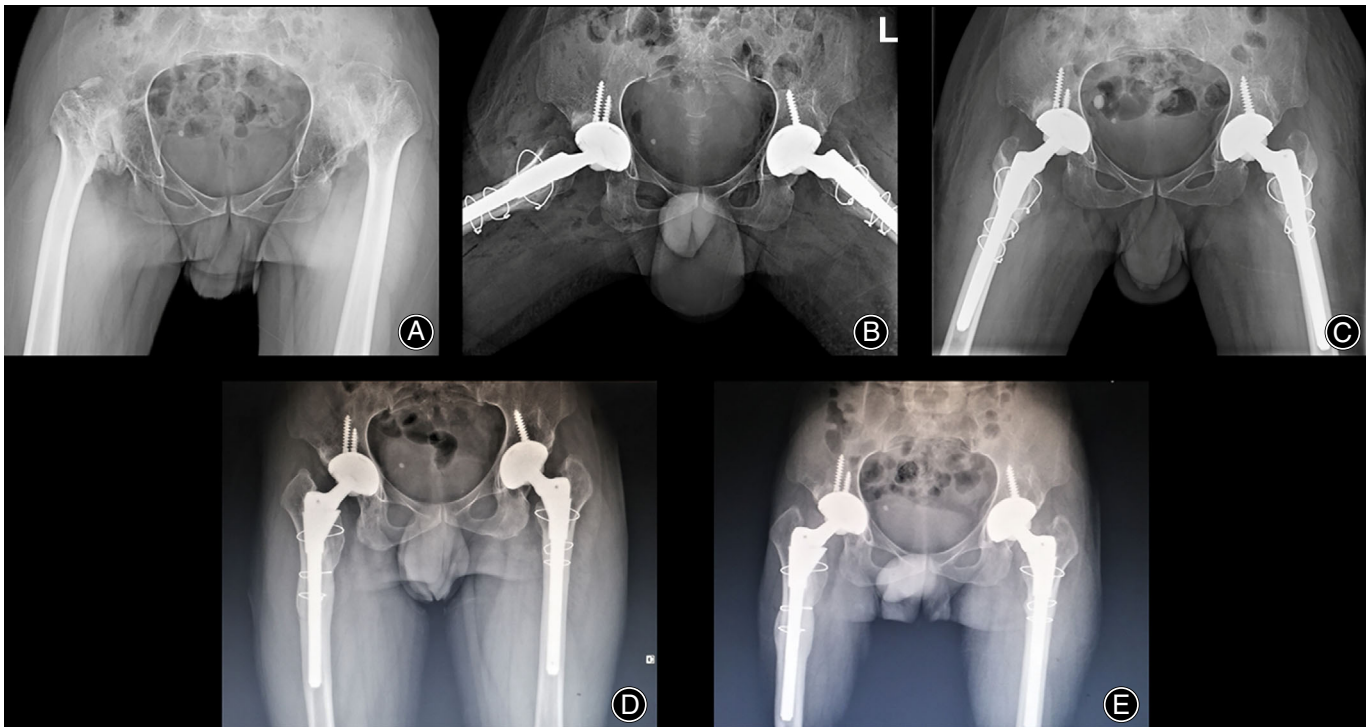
Compared with preoperative radiographs which demonstrated the pelvis was in sagittal anterior tilt (A), and radiographs taken immediately after THA (B) and in 3 months postoperatively (C) demonstrated the insignificant change of pelvic sagittal tilt. The radiographs taken in six (D) and 12 months (E) postoperatively demonstrated significant increase in H/W ratio and significant decrease in SSc, SC, and SSi distance, which showed the distinct change in pelvic sagittal posterior tilt
